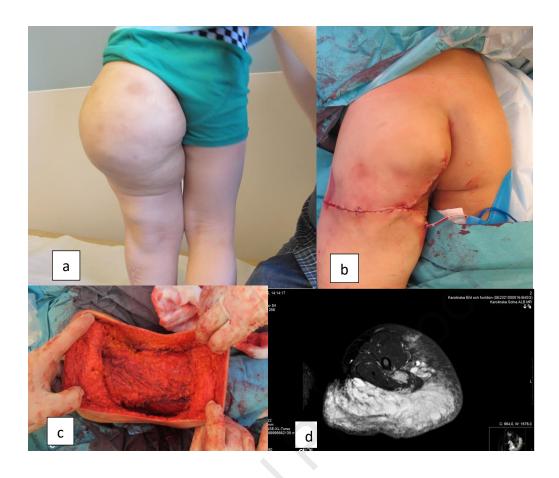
Microcystic LM: a Clinical feature in the gluteal region, b After surgical debulking, c Intraoperative view after resection of microcytic LM, d MRI T2 weighted image showing microcystic LM.
